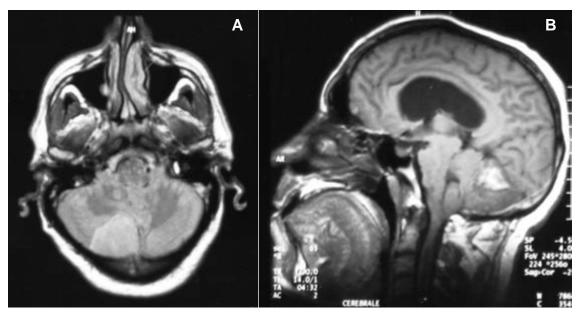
A) Axial MRI (at the initial presentation), showing a right hemispheric and vermian cerebellar lesion with mass effect on the fourth ventricle. B) Sagittal MRI (at the initial presentation) demonstrating a heterogeneous right hemispheric cerebellar lesion with hyperintense streaks due to the adipose content.
